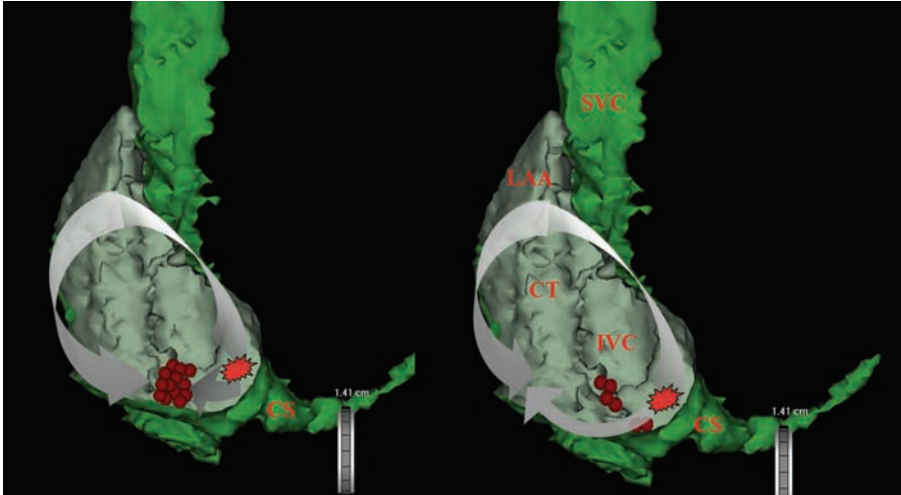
CT image of the right atrium clipped in LAO view. The right image shows the activation sequence after partial isthmus ablation with the presence of a gap. The left image shows complete unidirectional block.
